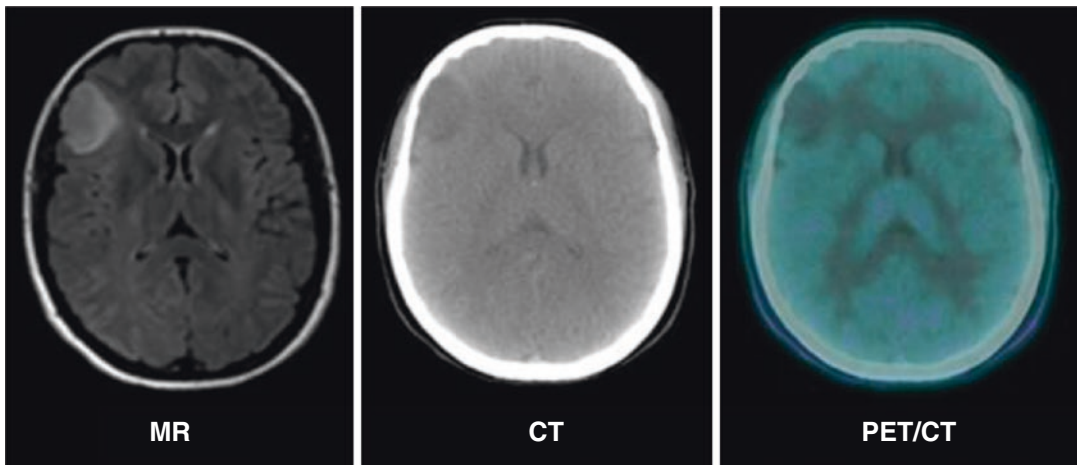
Low-grade glioma. PET/CT highlights an area of reduced uptake of ^{11}C -methionine in right frontal lesion, with tumor-to-normal ratio of 0.8
